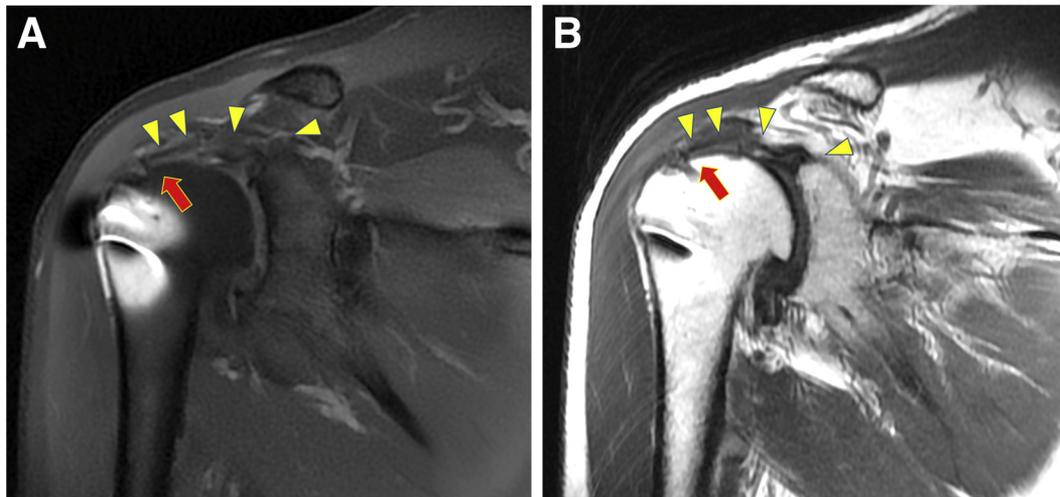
MRI of right shoulder on 2-year follow-up. Oblique coronal proton density with and without fat saturation reveals continuous fibers of the graft (arrow and arrowhead) from the anastomosis to the fixation screws. (A) With fat saturation. (B) Without fat saturation.
